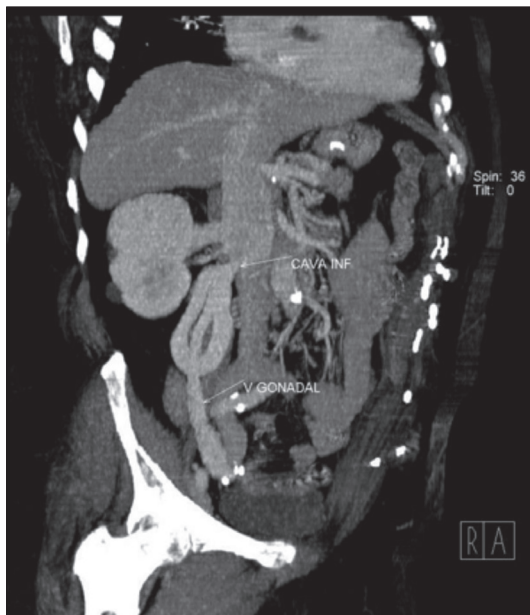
CT scan (coronal maximum intensity projection-MIP view): hypertrophy of right gonadal vein.
